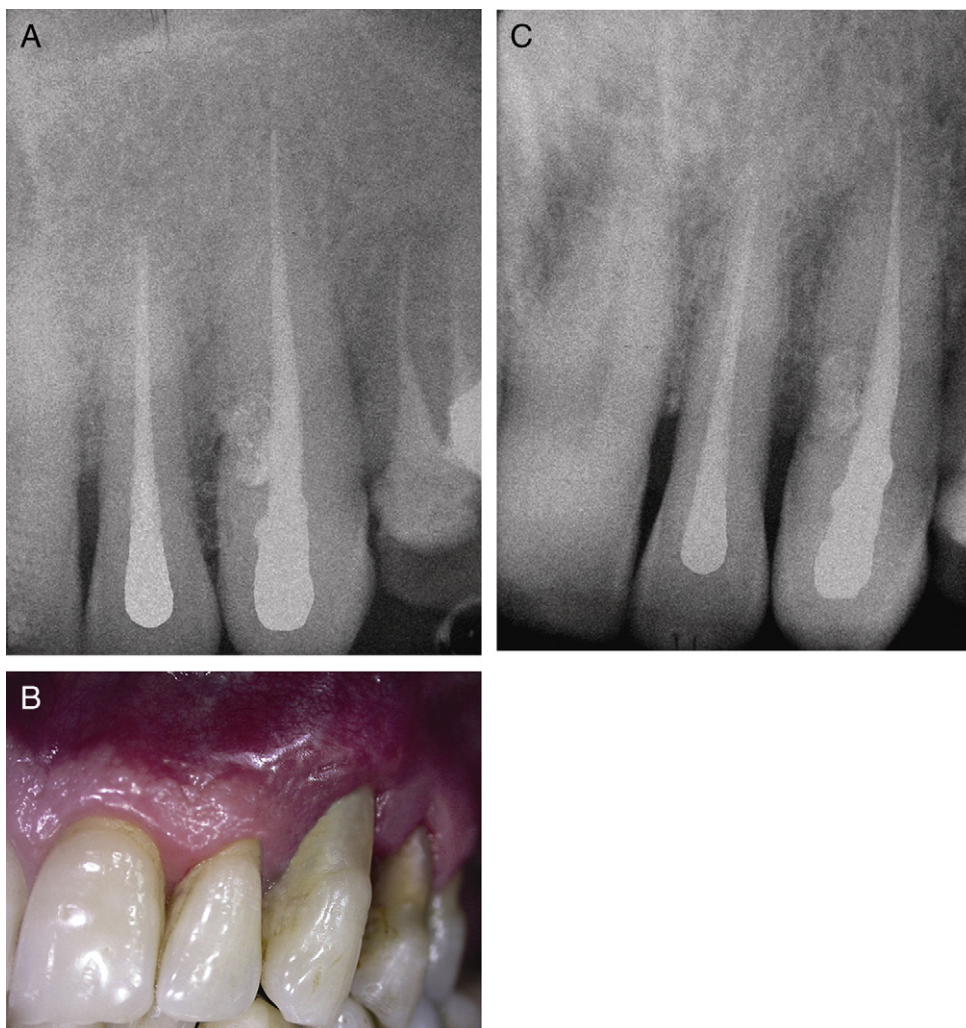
(A) Radiograph after obturation of the canal and filling defect with MTA. (B) Clinical situation after 1 year. (C) Radiographic follow-up after 1 year.
